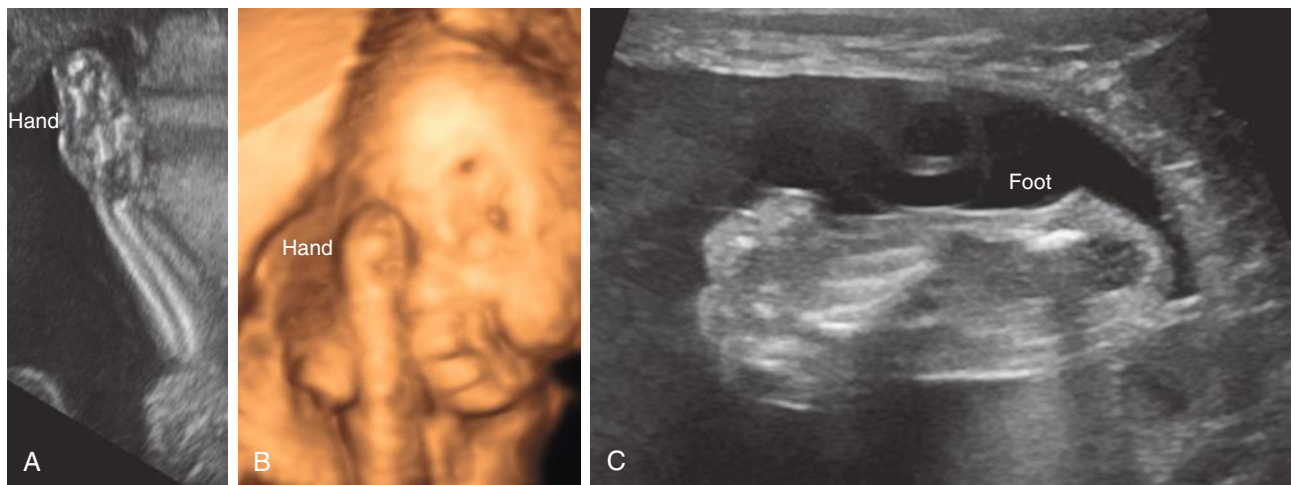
Apert syndrome. Syndactyly of the hand demonstrated with two-dimensional (2D) (A) and 3D (B) ultrasound images. Syndactyly of the foot is also present (C).
